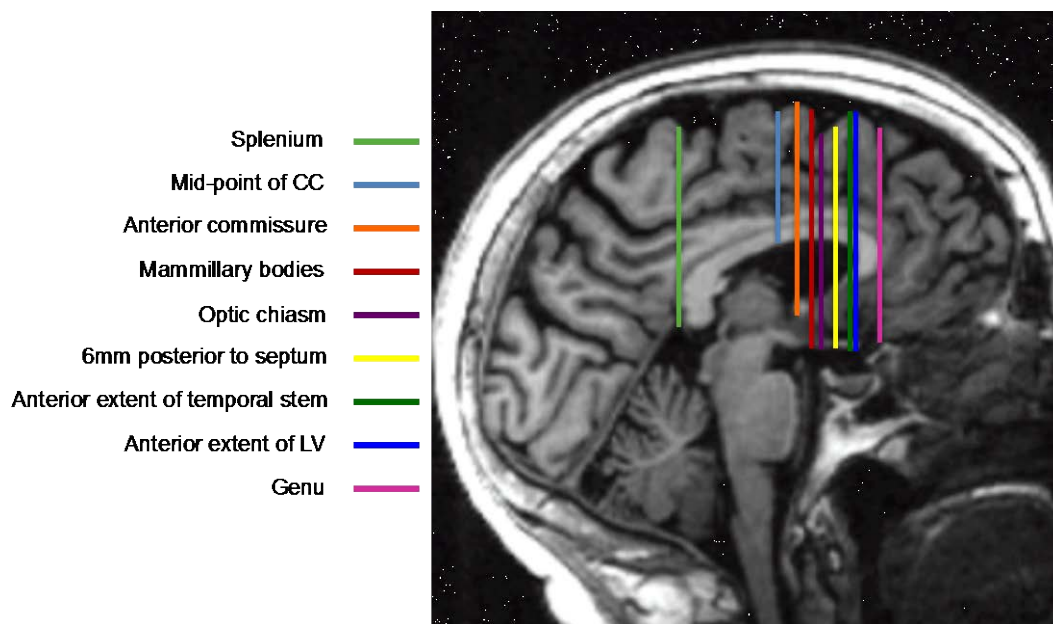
Variation of single cut plane boundaries displayed on a sagittal T1W MRI.
